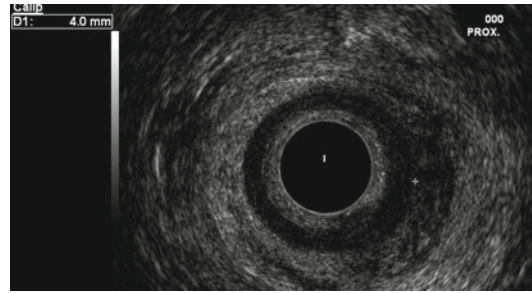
Endoanal ultrasound demonstrating thickened internal anal sphincter (4 mm) in a 50 year old woman (see calipers)
